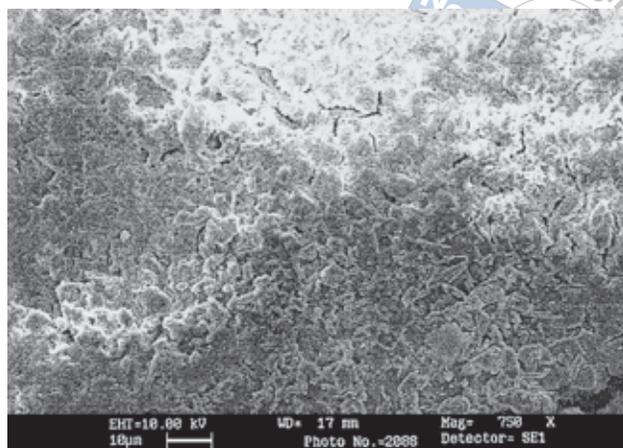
SEM image of ultrasonically treated root surface, 750X magnification. Note the cracks on this surface.
